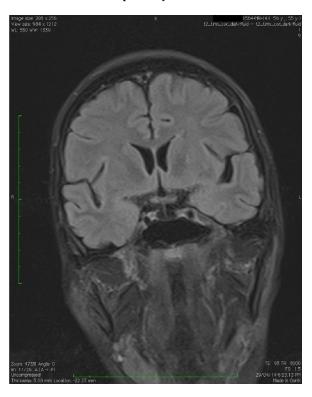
Coronal section of MRI Brain showing empty sella with intact posterior pituitary
